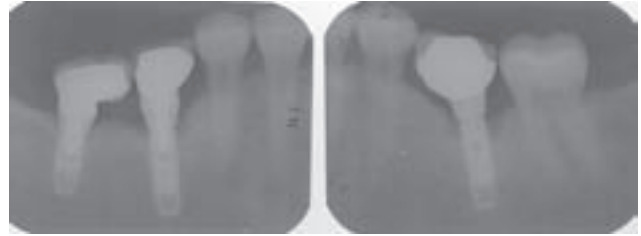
Radiographic images of posterior mandibular implants replacing molar teeth. Bone loss associated with the implants in positions 19 and 30 was determined to be associated with implants that were partially fractured at the level of the abutment screw. Fracture was likely due to fatigue caused by bending moments generated by the wide occlusal platform of the implant-supported restorations.
